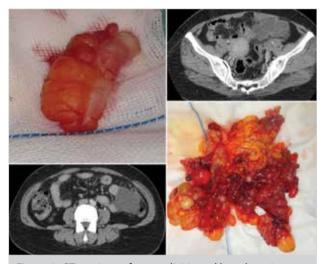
CT sections of appendicitis and lymphangioma and appendectomy material
